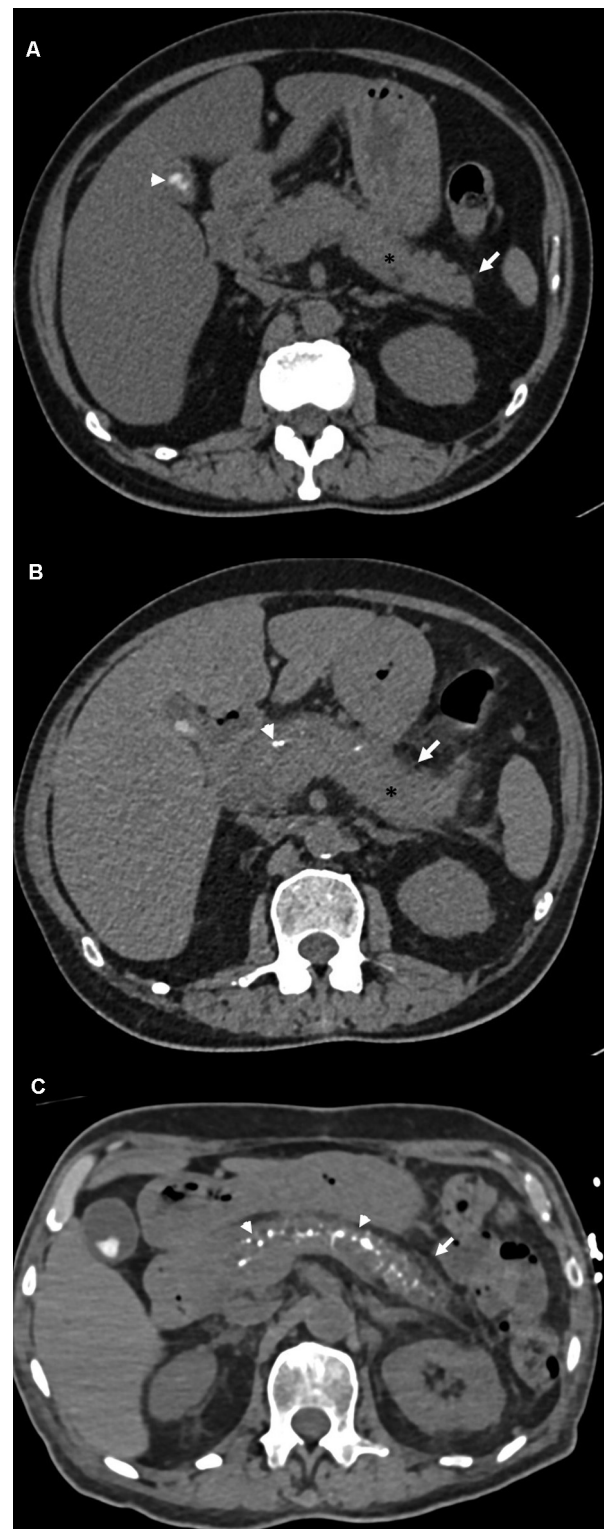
Computed tomography (CT) in 62/M showing alcohol-related rapid progression to chronic pancreatitis in 2 years, due to a continuous history of alcohol abuse. (A) Noncontrast-enhanced CT (NECT) in axial plane shows the pancreas of normal bulk but has peripancreatic fat stranding (white arrow) suggesting mild acute pancreatitis. (B) NECT of the same patient done after 1 year following a binge, shows increased bulk of the pancreas (black star) with significant peripancreatic fat stranding (white arrow). New calcification is seen (white arrowhead). (C) NECT of the same patient done after 18 months shows reduced bulk of the pancreas and significantly increased calcifications (white arrowhead).
